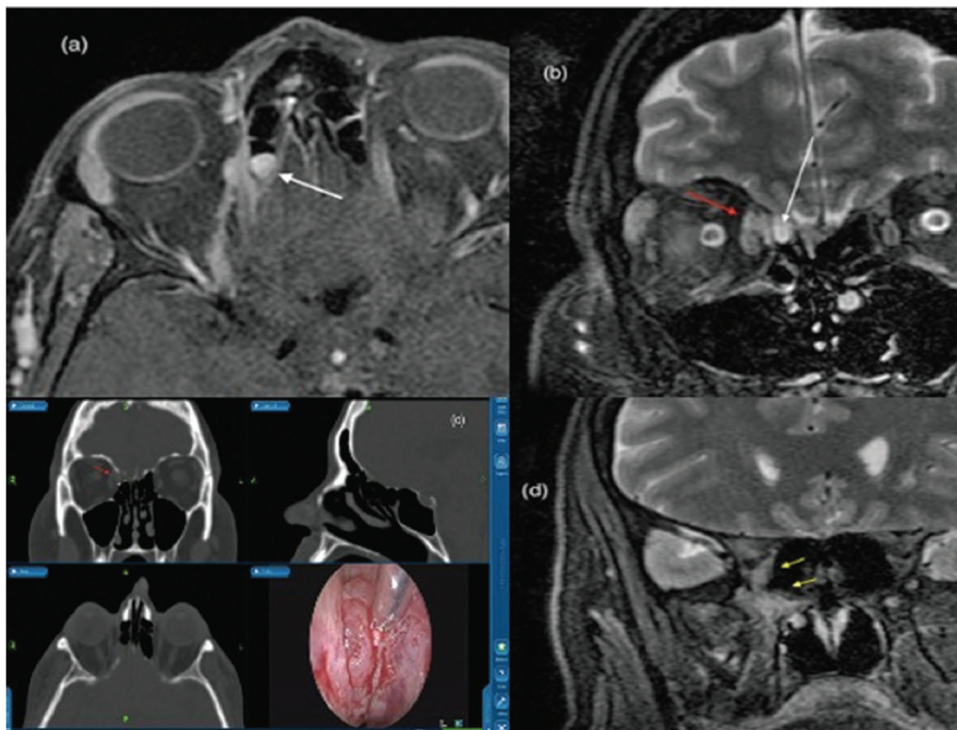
Case 2: (a) Preoperative axial postgadolinium T1-weighted MRI and (b) coronal T2-MRI and (c) intraoperative neuronavigation multiplanar images demonstrating a tiny ethmoidal tumor (white arrow) that affects the orbit (red arrow) through an almost intact lamina papyracea (asterisk). (d) Linear intraorbital extension through nasociliary nerve to the apex area invading pterygopalatine fossa and extending to cavernous sinus. MRI, magnetic resonance imaging. Note: Yellow arrows indicate the intraorbital extension.
